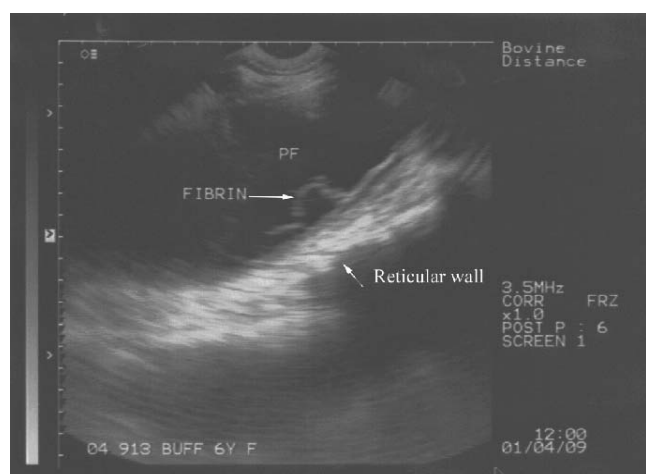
Ultrasonogram in B mode showing morphological changes in the reticular wall along with fibrin floating in the anechoic peritoneal fluid
